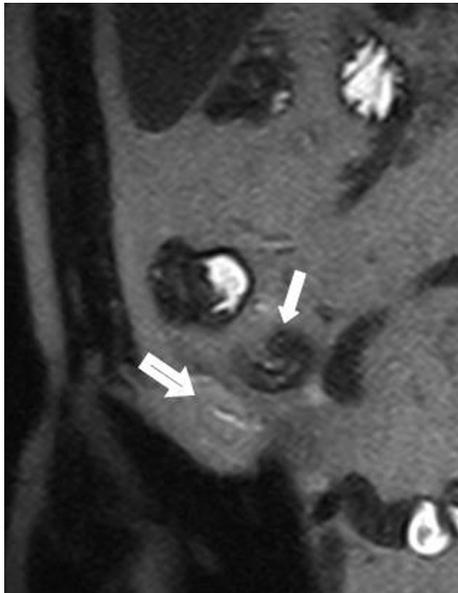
A 35-year-old man with severe right lower quadrant pain. Surgically confirmed extensive acute suppurative appendicitis. Coronal T2-weighted HASTE image shows fluid-filled appendix and thickened wall of appendix (solid arrow). Also note hyperintense periappendiceal inflamed fat (open arrow). Inflamed appendix is not shown at sonography due to poor sonic window related to patient's obesity.
